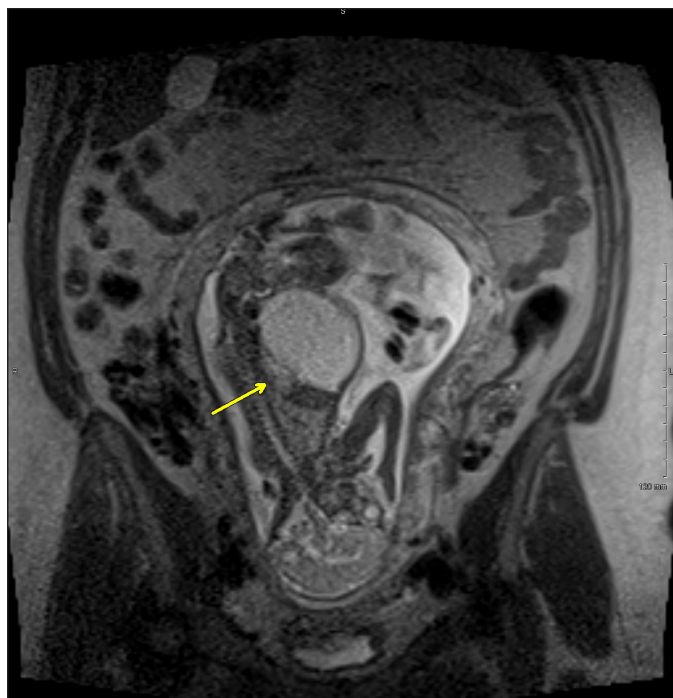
Prenatal MRI at week 22 of gestation showing coronal image of the mother and sagittal image of the fetus. A T2 hyperintense structure (arrow) appears within the fetal abdominal cavity inferior to the liver and anterior to the kidney.
